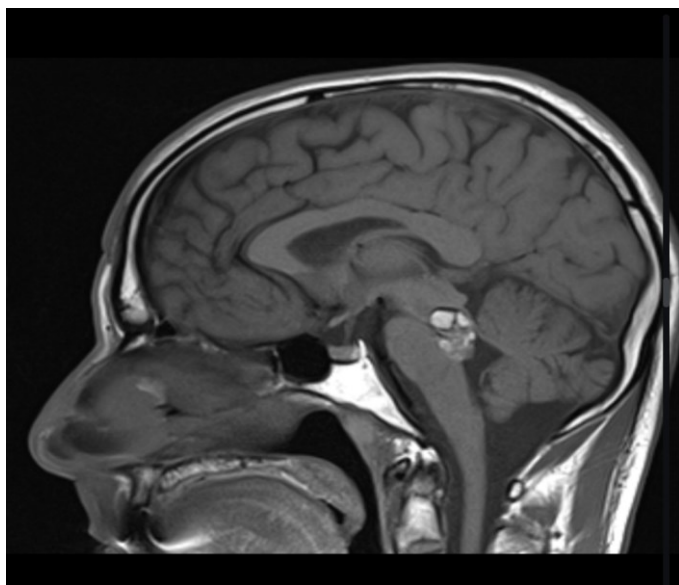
Cerebral tumor evidence by MRI scan. [5]
